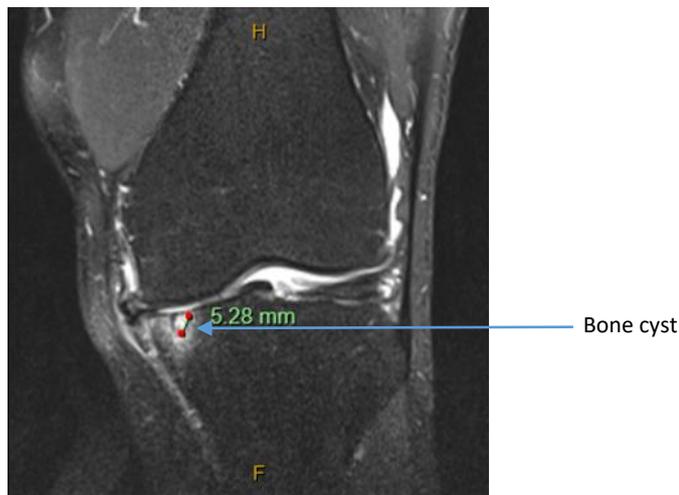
Subchondral medium cyst in the central tibia on T2 weighted coronal image (MRI image of a study participant).
